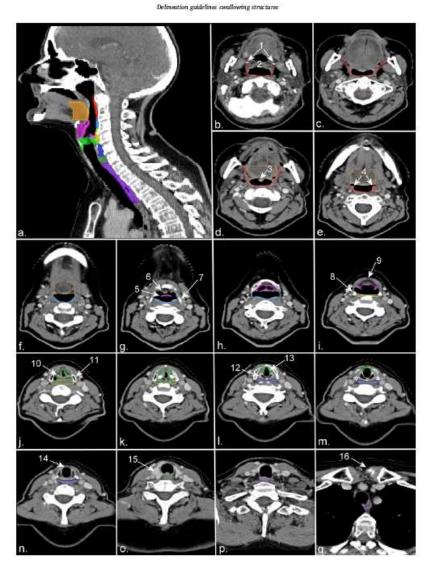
Most relevant CT-slices for the delineation of SWOARs, including; superior PCM (red); middle PCM (light blue); inferior PCM (thyropharyngeal part) (yellow); cricopharyngeus (dark blue); ElM (dark green); CE (purple); base of tongue (orange) and; supraglottic (pink) and glottic larynx (light green). The following reference anatomical structures are shown: (1) hamnins of pierygoid plates; (2) soft palate, (3) wula, (4) palatopharyngeal folds, (5) tip of epigloitis, (6) lingual tonsil, (7) greater horn of hyoid bone, (8) superior horn of thyroid cartilage, (9) pre-epigloitis space, (10) arytenoid artitige, (11) thyroid cartilage, (12) cricoid cartilage, (13) soft issue of lower larynx, (14) no soft tissue present anterior to cricoid cartilage, (15) thyroid gland, and (16) sternal notch.
